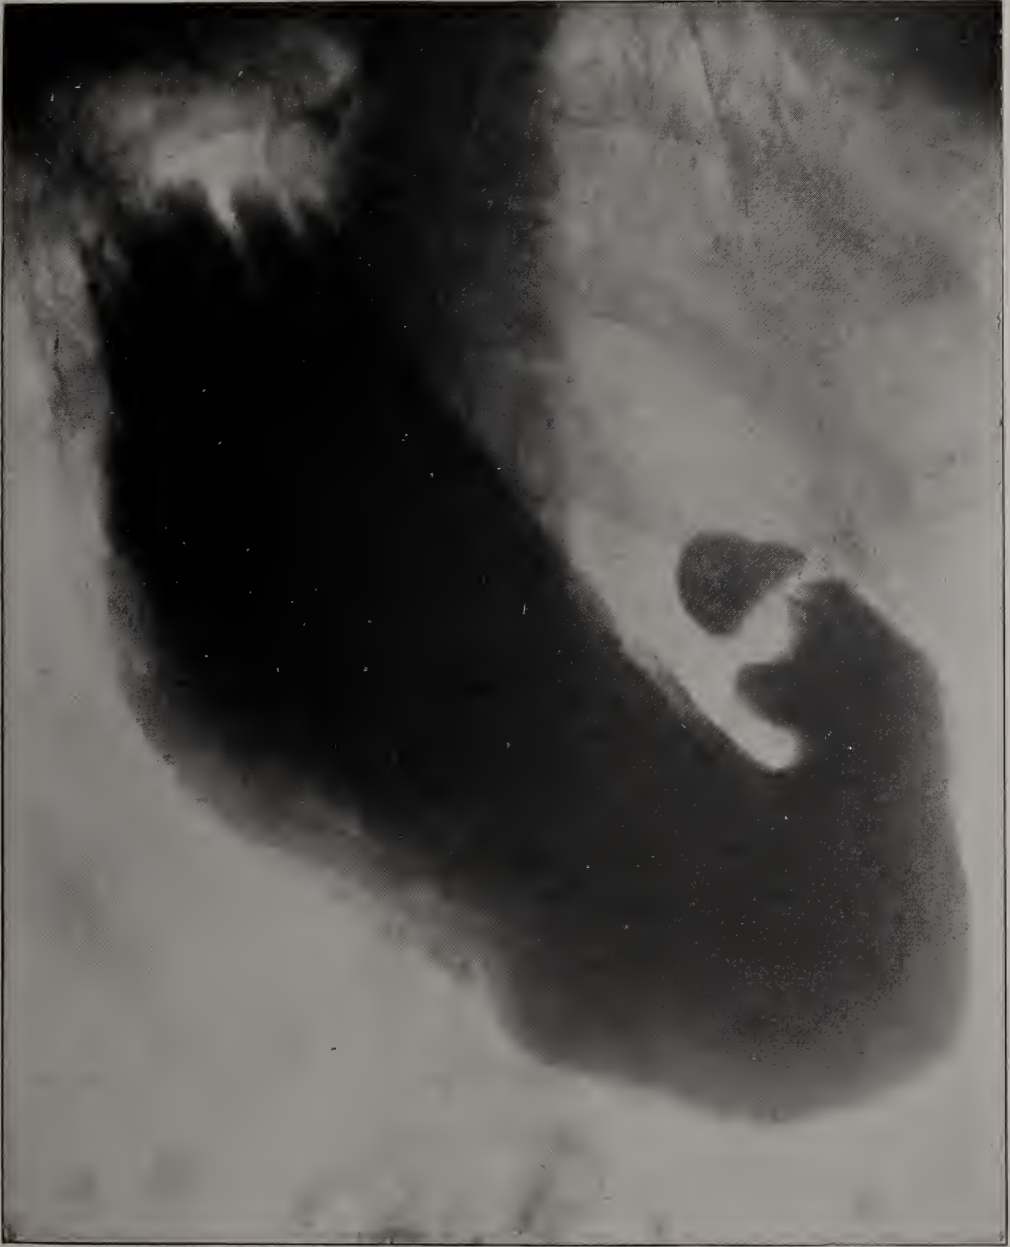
Clinical diagnosis: Duodenal ulcer. Roentgen diagnosis: "Duodenal cap normal. Fixed position of stomach far over to the right, due to adhesions probably from gall-bladder." Operation showed adhesions around the gall-bladder.
